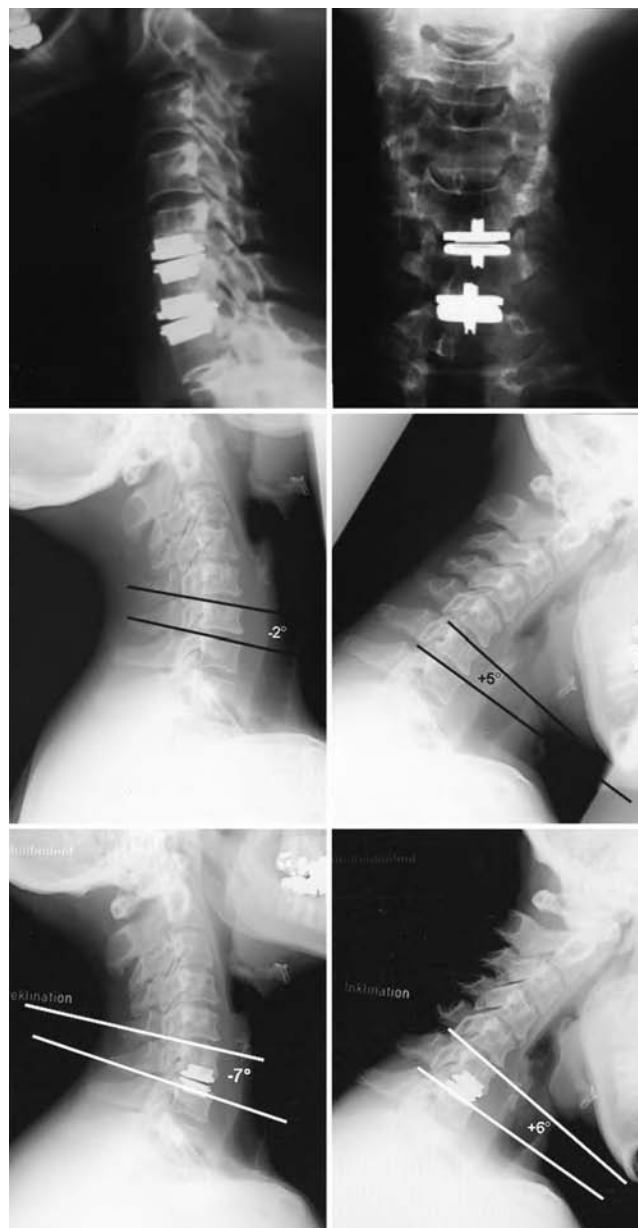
Lateral (upper left) and AP (upper right) 1-year postoperative radiographs. Preoperative flexion (center left) and extension (center right) radiographs showed a total motion of 7°. One-year postoperative flexion (lower left) and extension (lower right) radiographs demonstrated a total motion of 13°.
